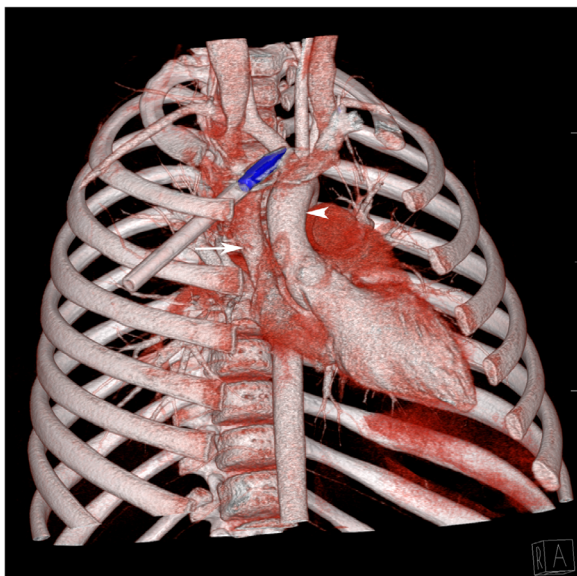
Reconstructed computed tomography (CT) coronal oblique: Volume rendered 3-dimensional image of the chest in the coronal oblique plane. Obtained using post-processing software on the chest CT angiogram. The metallic tip of the bolt is blue. Notice how close in proximity the bolt is to the thoracic vasculature, including the aorta (marked with an arrowhead) and its branches. Along the inferior margin and just behind the bolt is the superior vena cava (marked with an arrow)
